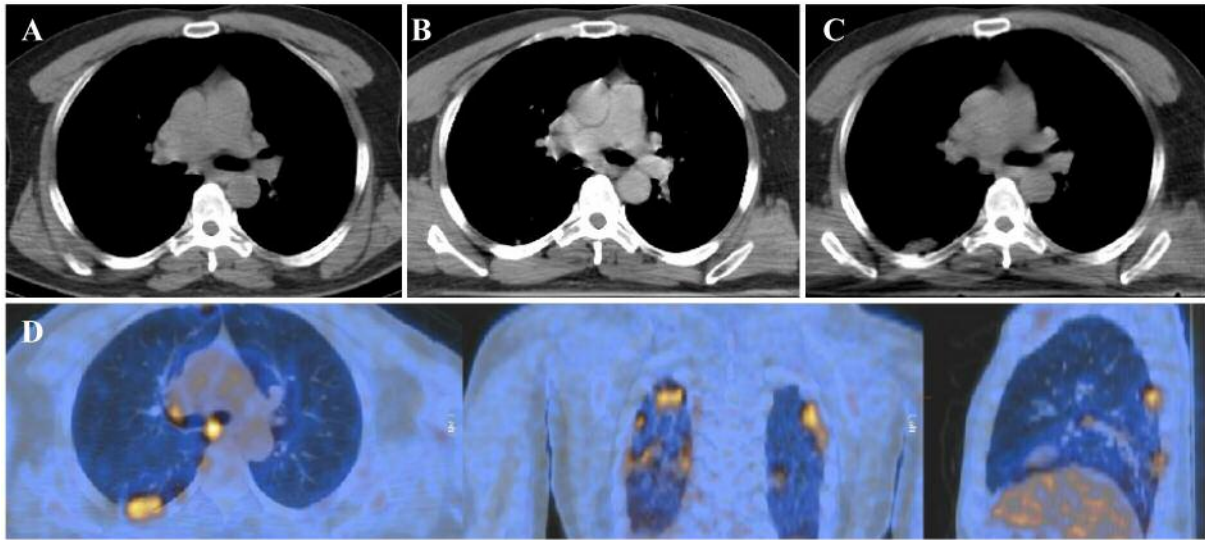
^{18}F -Fluorodeoxyglucose-avid pulmonary opacities incidentally discovered on positron-emission tomography computed tomography (PET/CT). A: Axial view of low-dose CT scan, 1 month prior to PET/CT. B: Axial view of CT scan 12 days prior to PET/CT. C: Axial view of low-dose CT scan from PET/CT. D: Fused images from PET/CT scan.
